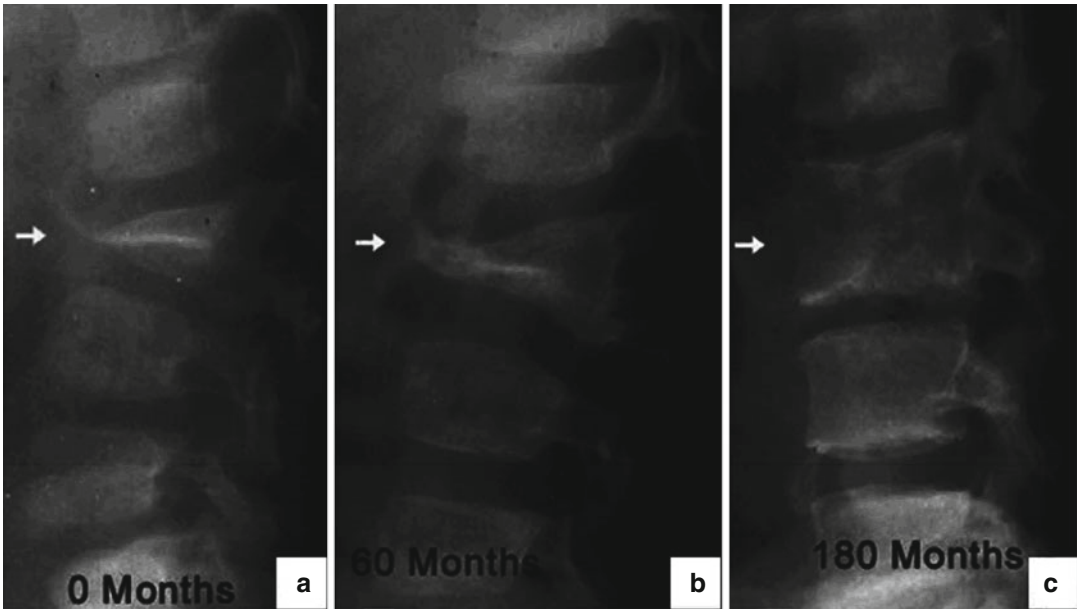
Type A restabilization. In patients with partially destroyed vertebrae, restabilization occurs with wide contact area and the kyphosis gets corrected automatically or remains unchanged. (a) Lateral radiograph of thoracolumbar spine showing a healed tuberculous lesion at L2-3 which has healed into a triangle shaped fusion mass (*arrow*). The
